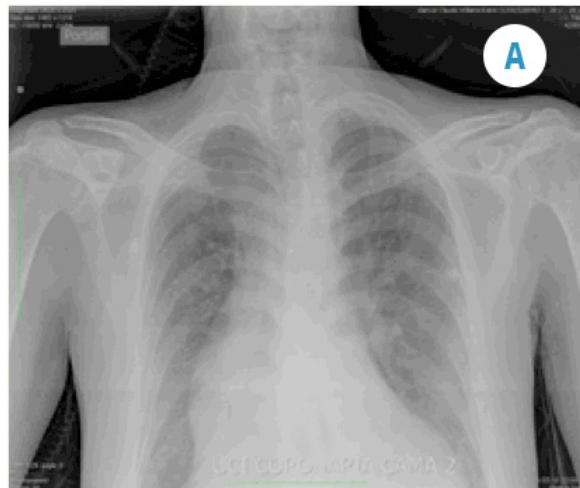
Posteroanterior chest radiograph. Grade 4 cardiomegaly and mediastinal widening at the expense of ascending aorta.
